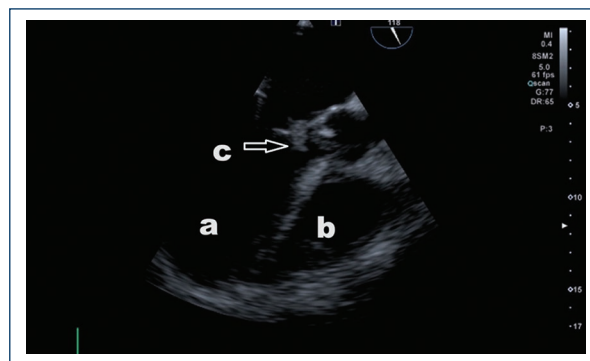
Transthoracic echocardiogram image (parasternal long-axis view). a: left ventricle, b: left atrium, c: vegetation in a large aortic valve of 3.2 cm (arrow).
